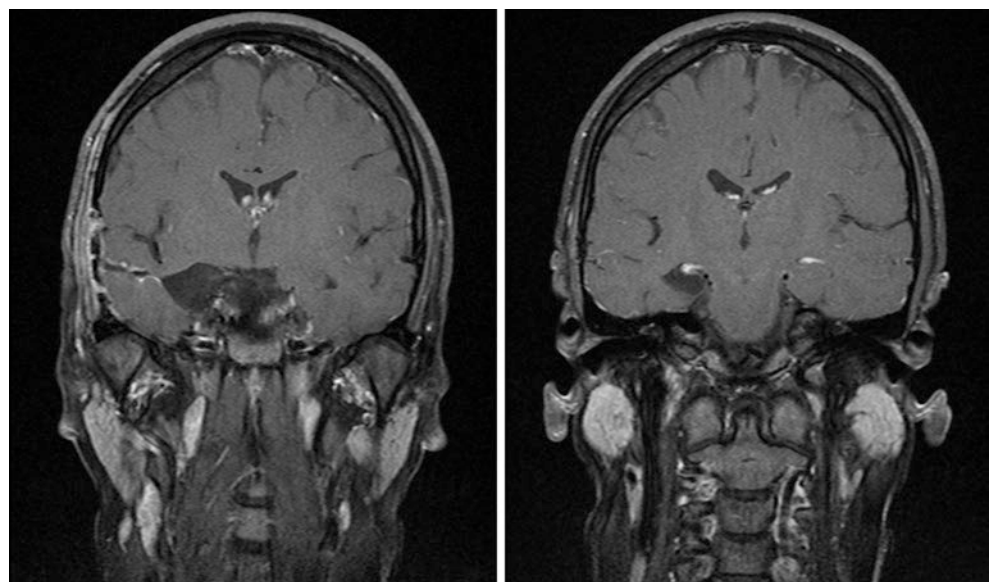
Coronal MRI after right-sided trans-sulcal selective amygdalohippocampectomy
